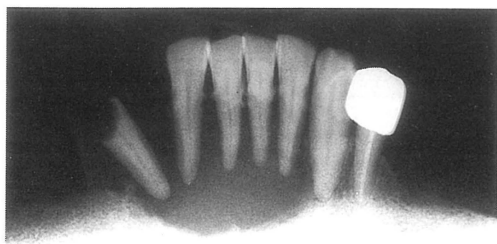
Roentgenogram showing bone resorption with a well defined boundary (Case 1).
